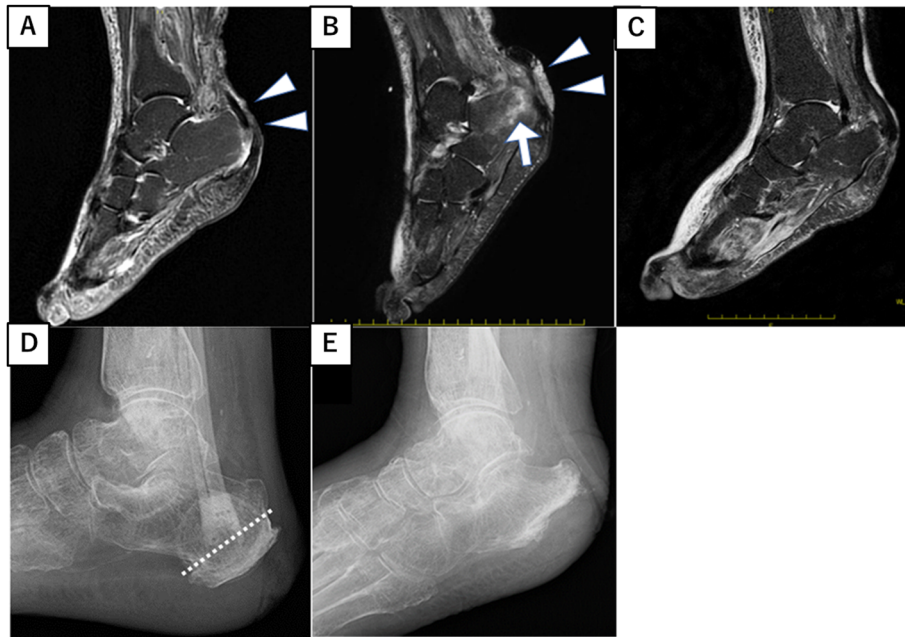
Magnetic resonance imaging findings of the right foot (T2-STIR images). No osteomyelitis was observed at admission (A). Right calcaneal osteomyelitis developed (arrow) three months after the bypass surgery (B). Arrowheads indicate the location of the heel ulcer. After partial calcaneotomy, no osteomyelitis was observed after wound healing (C). Foot radiography before (D) and after (E) partial calcaneotomy. The dotted line indicates the cutting line of the heel bone.
